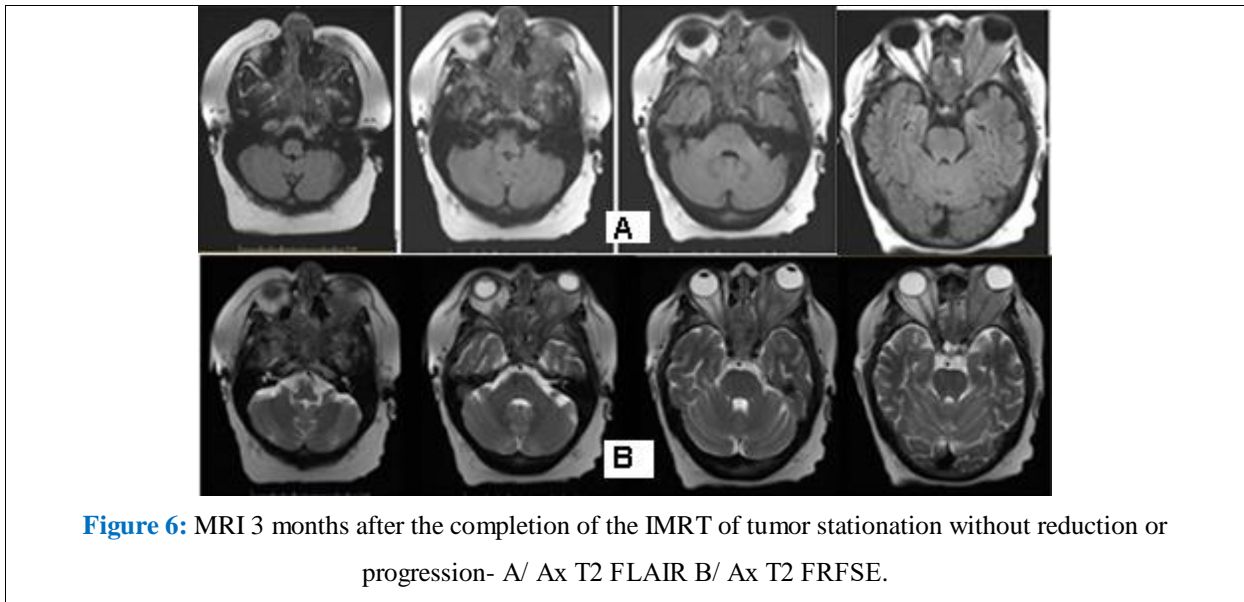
MRI 3 months after the completion of the IMRT of tumor stationation without reduction or progression- A/ Ax T2 FLAIR B/ Ax T2 FRFSE.
